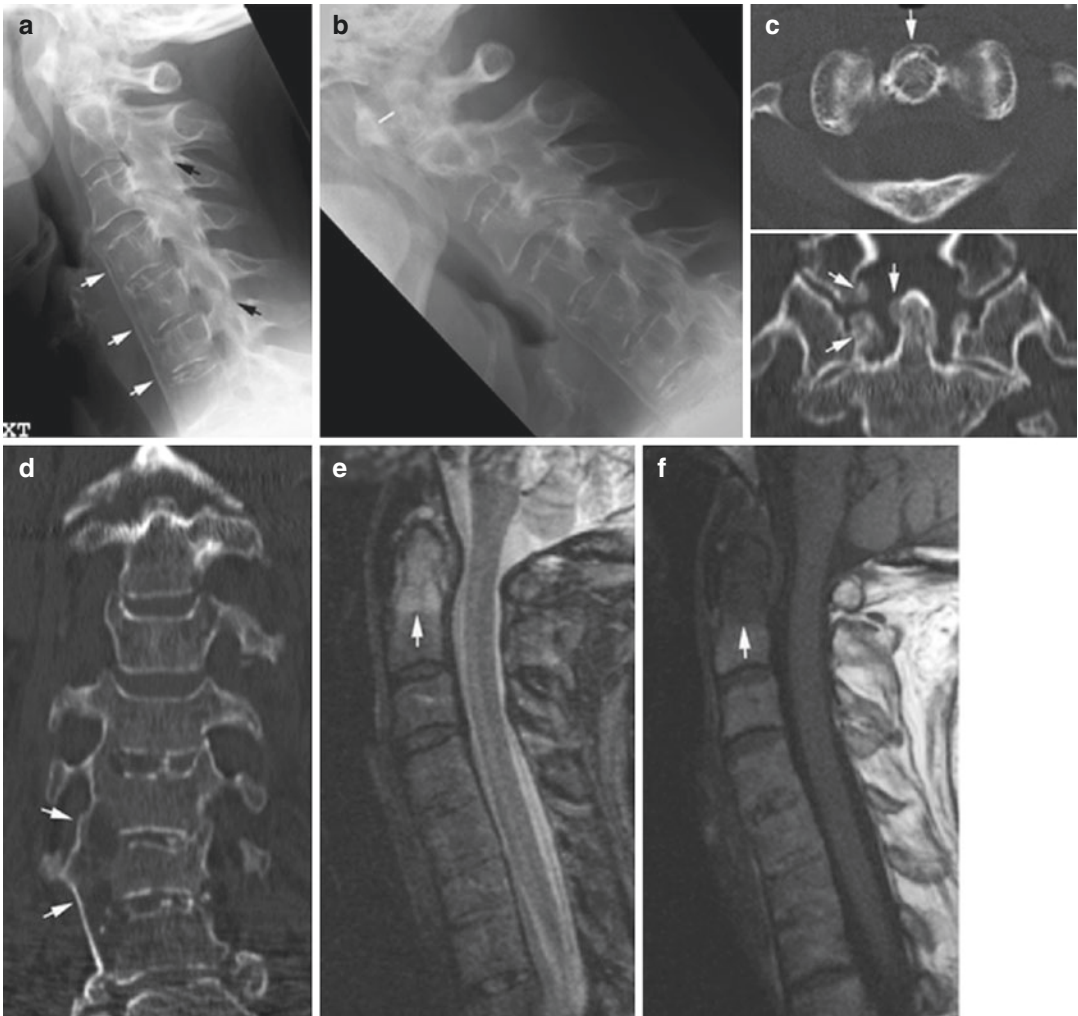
Lateral cervical radiographs obtained in neutral position (a) and with flexion (b) in a 61-year-old woman with PsA demonstrate thick, anterior syndesmophytes (white arrows), fusion of the facet joints (black arrows), and abnormal increase in the distance between the anterior arch of C1 and the dens with flexion (4 mm, white line in b), indicating instability. Corresponding axial (c) and coronal (d) CT images demonstrate new
